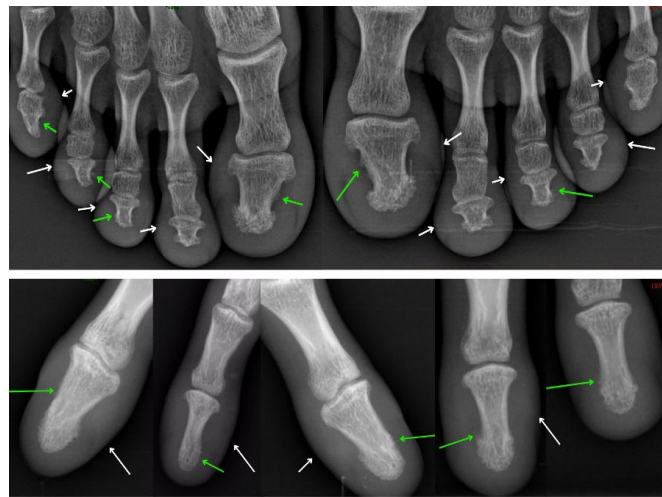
X-rays manus and pedis bilateral showed minimal solid periosteal reaction on the distal phalanges of the fingers and toes bilaterally with soft tissue swelling.
